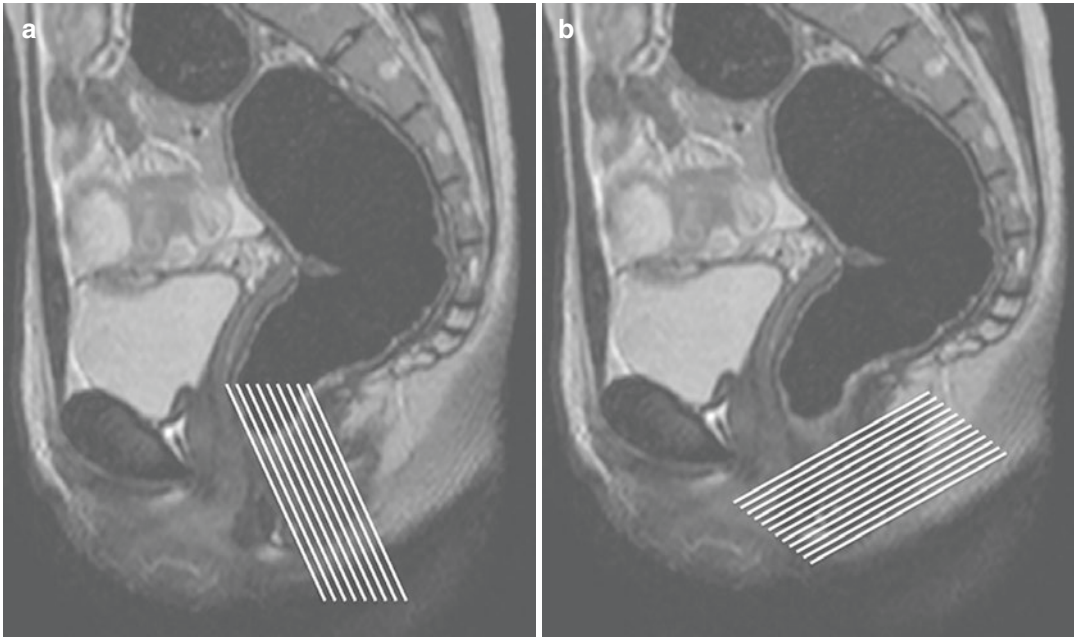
Technique. Orientation of coronal (a) and axial (b) scan series on a midline sagittal T2-weighted TSE image, respectively, parallel and perpendicular to the major axis of the anal canal
